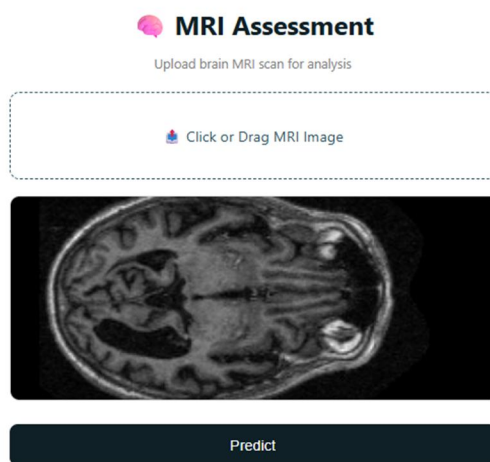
MRI Assessment Page
